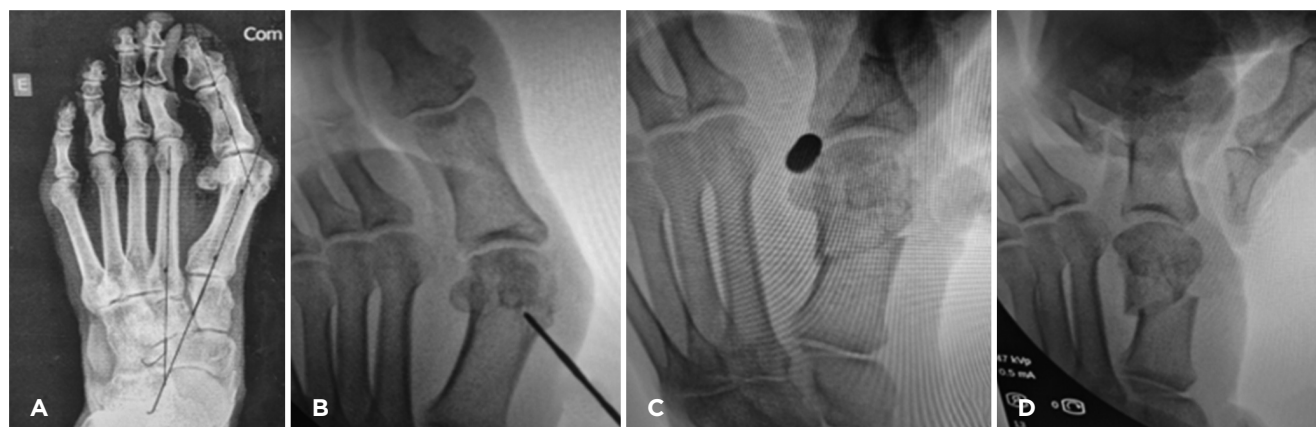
(A) Radiograph showing the moderate hallux valgus, (B) intraoperative radiograph demonstrating the point of onset of osteotomies, (C) radiograph after the RImod technique with lateral displacement of the metatarsal head and entry point of the tenotomy, (D) intraoperative radiograph showing the final result.
